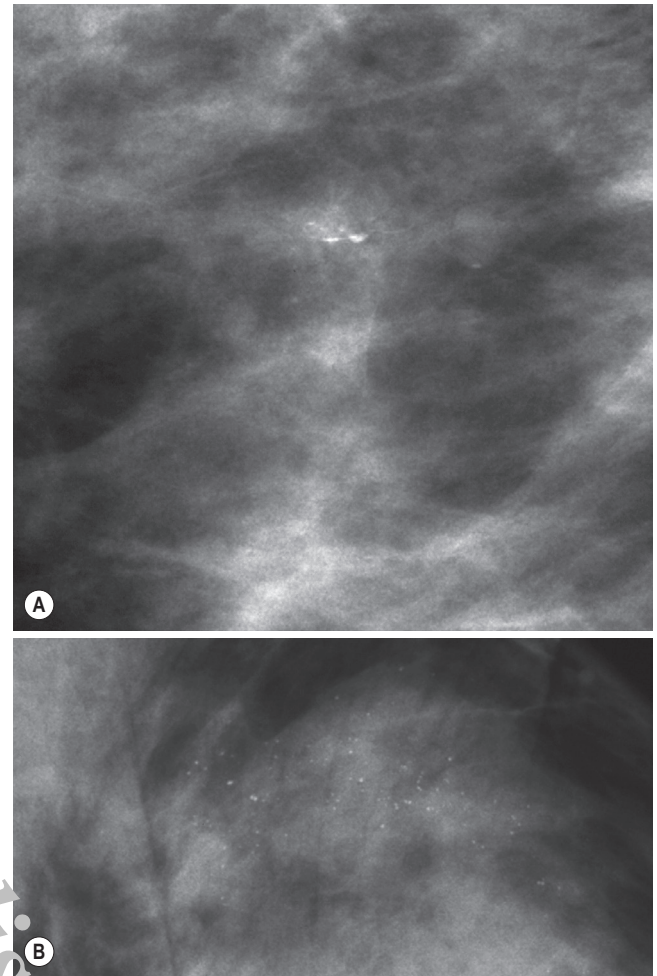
Fibrocystic Change. (A) 'Teacups' representing the layering out of calcific material in the dependent portion of microcysts on a lateral magnification view. (B) Calcifications associated with areas of fibrocystic change may not exhibit this characteristic appearance so x-ray guided biopsy may be required.
